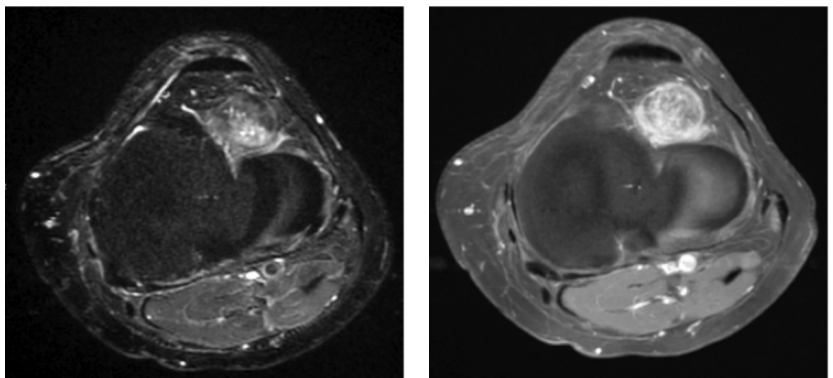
72-year-old man with giant-cell tumor of the tendon sheath. MRI shows findings typical of intra-articular GCTTS (PVNS). Left: Transaxial MR inversion recovery. Right: T1-weighted fat saturation imaging postgadolinium.
